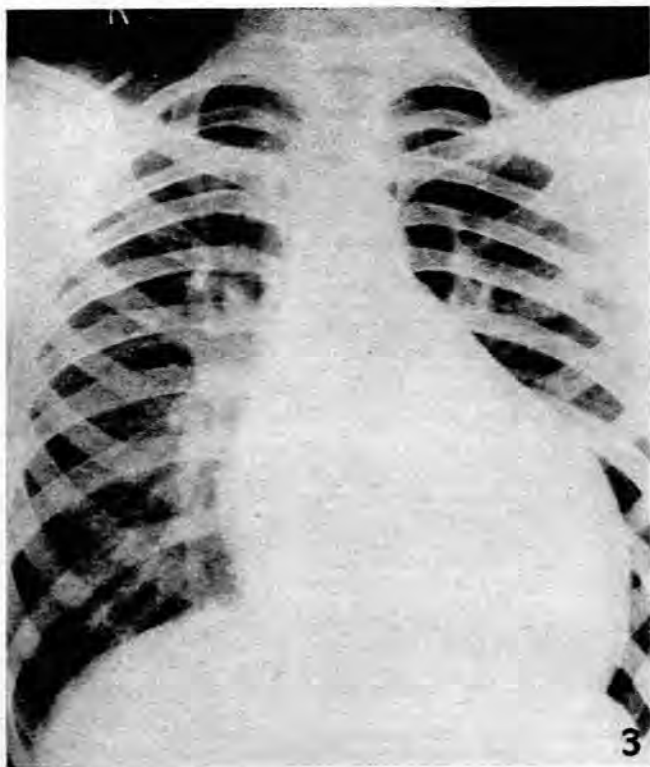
X-ray of heart, 12 October 1956, showing dilated pulmonary arteries, marked pulmonary plethora, and enlargement of right and left ventricles.
